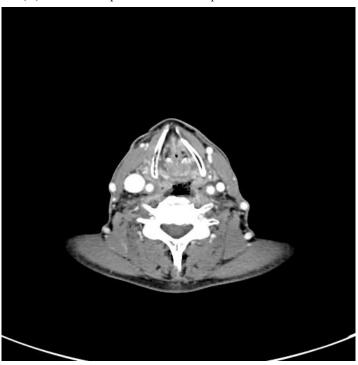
Contrasted neck CT at 6 months postchemoradiotherapy demonstrated no evidence of disease with soft tissue air indicating radiation necrosis and ulceration.
